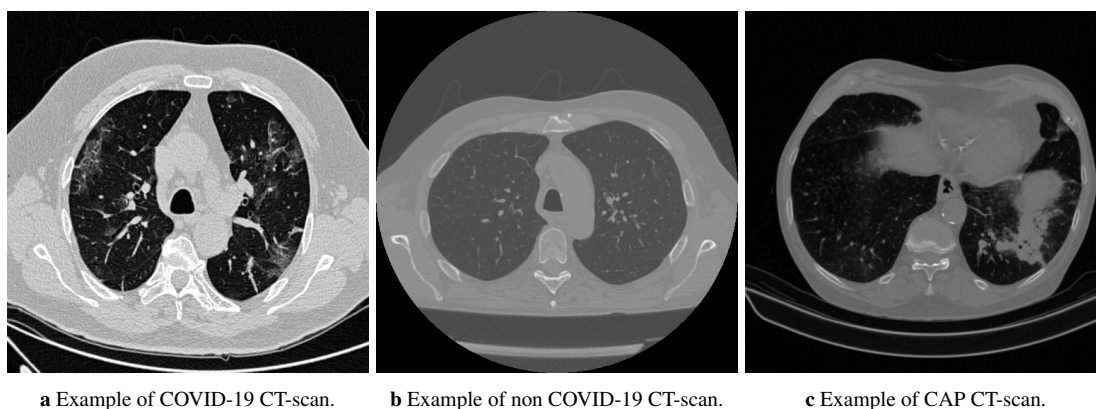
Examples from CT-scan dataset of Multi-class classification [46].
